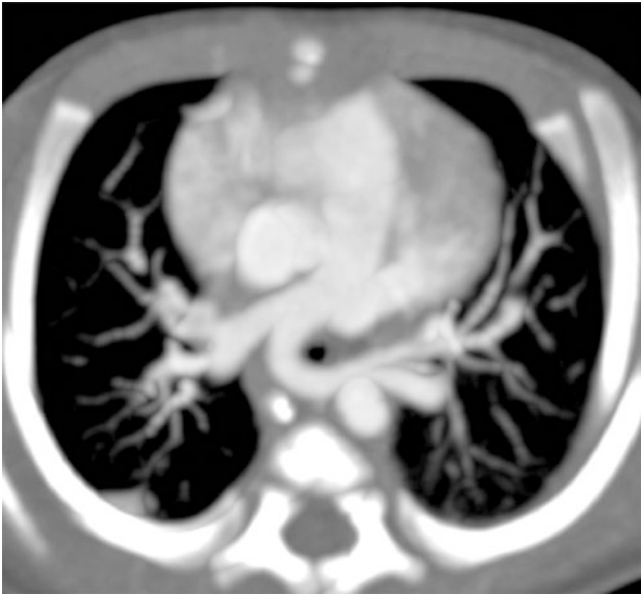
Left pulmonary artery sling in a neonate, contrast-enhanced CT. The left pulmonary artery passes behind the trachea and anterior to the oesophagus (Note contrast in the nasogastric tube)
